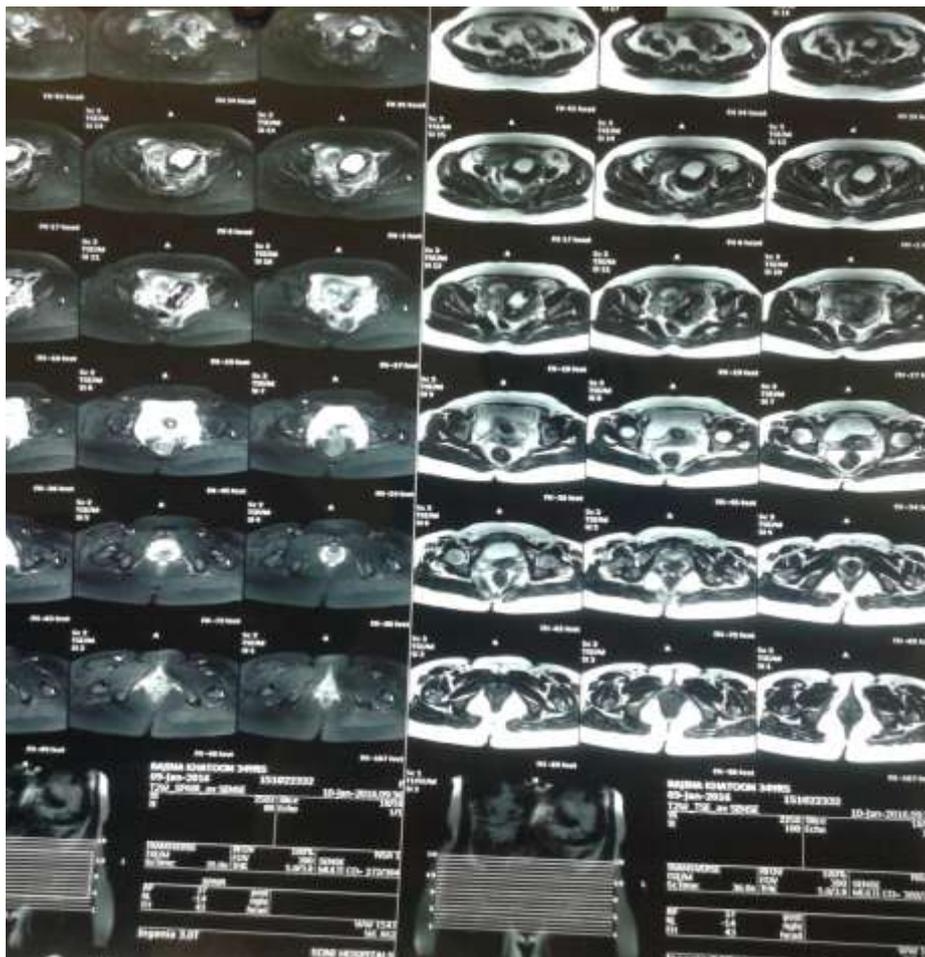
MRI Pelvis Showing Gravid Uterus with Sub-Chorionic Haemorrhage, Left Adenaxal Mass With Anechoic Area And Vascularity
